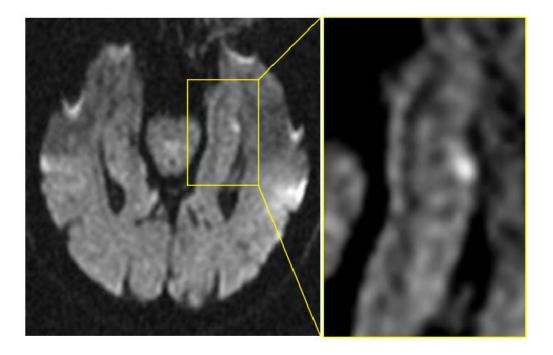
Images from 1.5-Tesla diffusion-weighted magnetic resonance imaging (MRI) showing a small, punctate hyperintense lesion in the body of the left hippocampus in patient G.Z. 21 hours after the onset of the amnestic attack.
